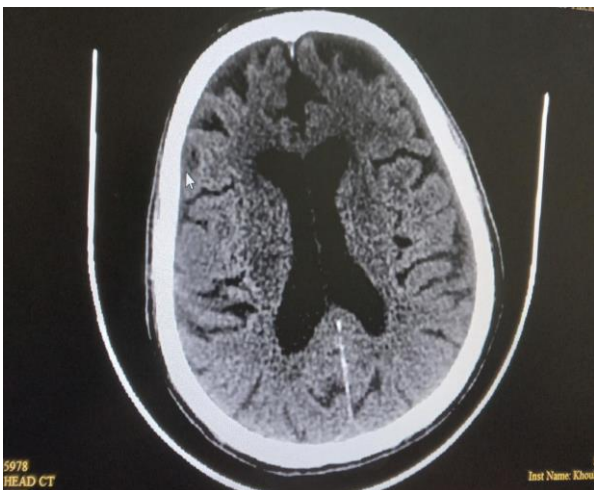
CT Brain Showing Total Resolution of Chronic Subdural Haemorrhage After MMA Embolization.
